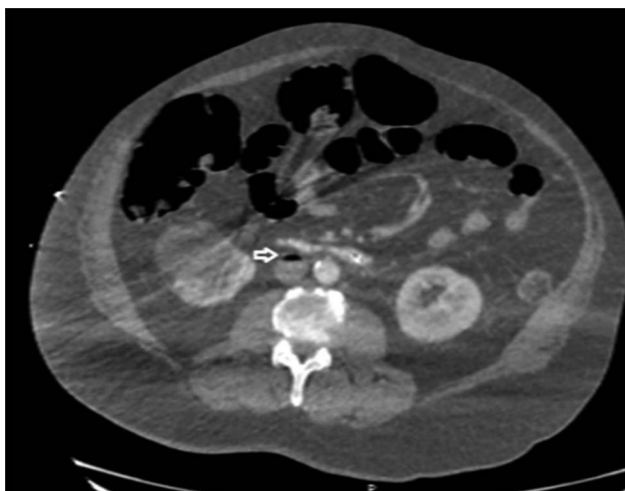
Computed tomography angiography performed after the patient stabilized demonstrated air within the inferior vena cava.
